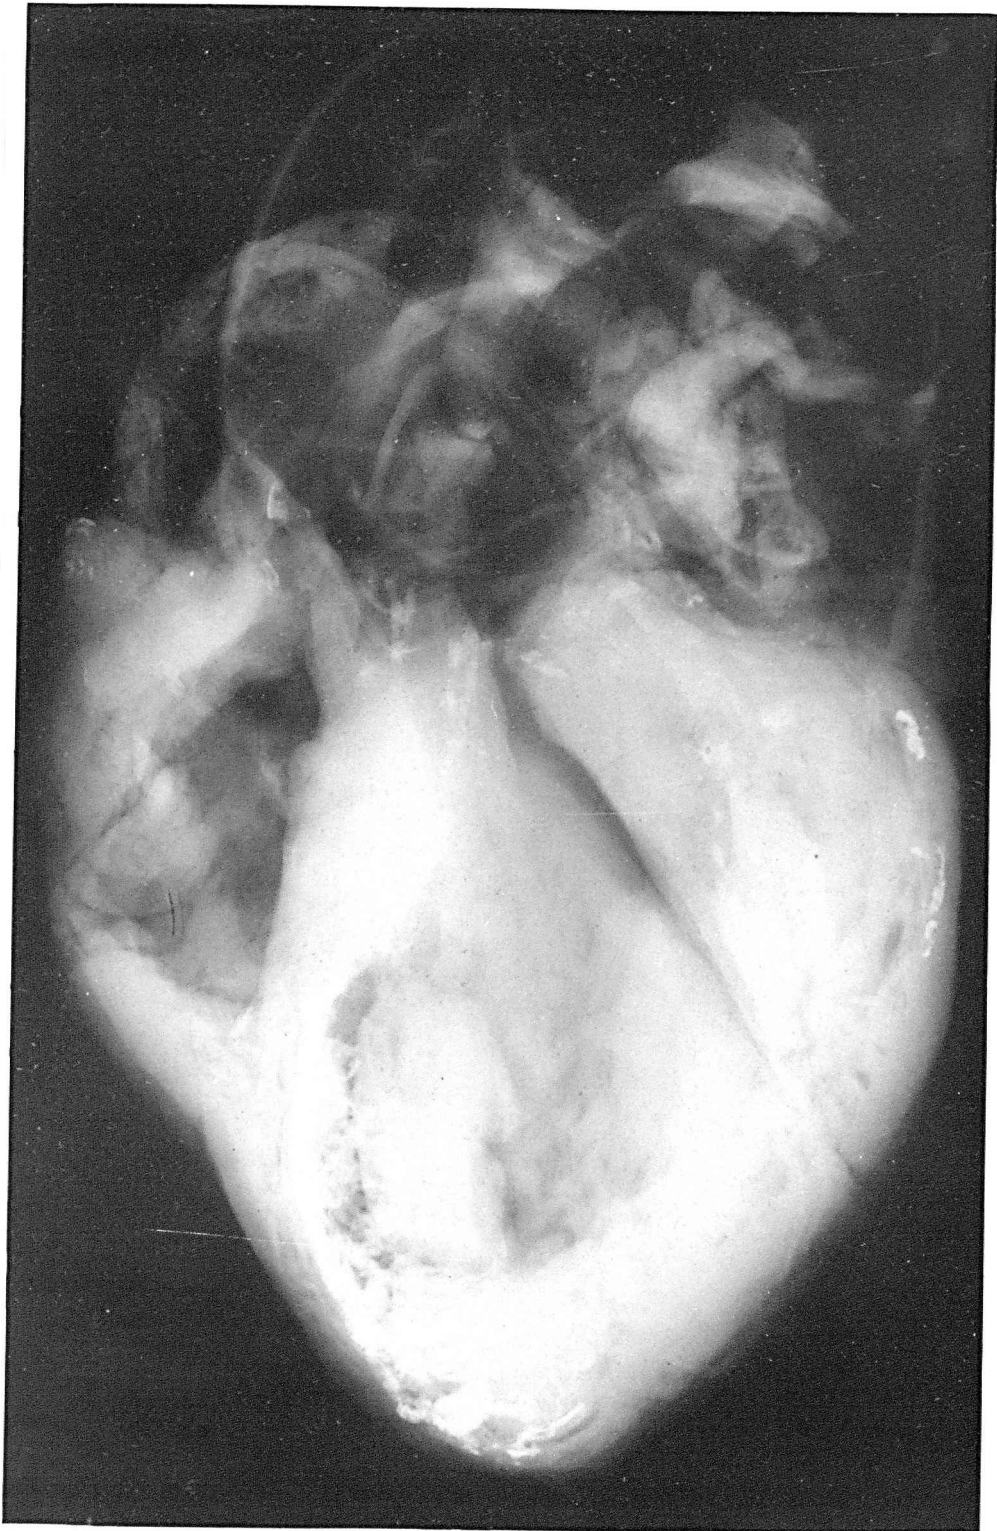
Antero-posterior radiograph of the heart. Note the calcified coronary arteries.
